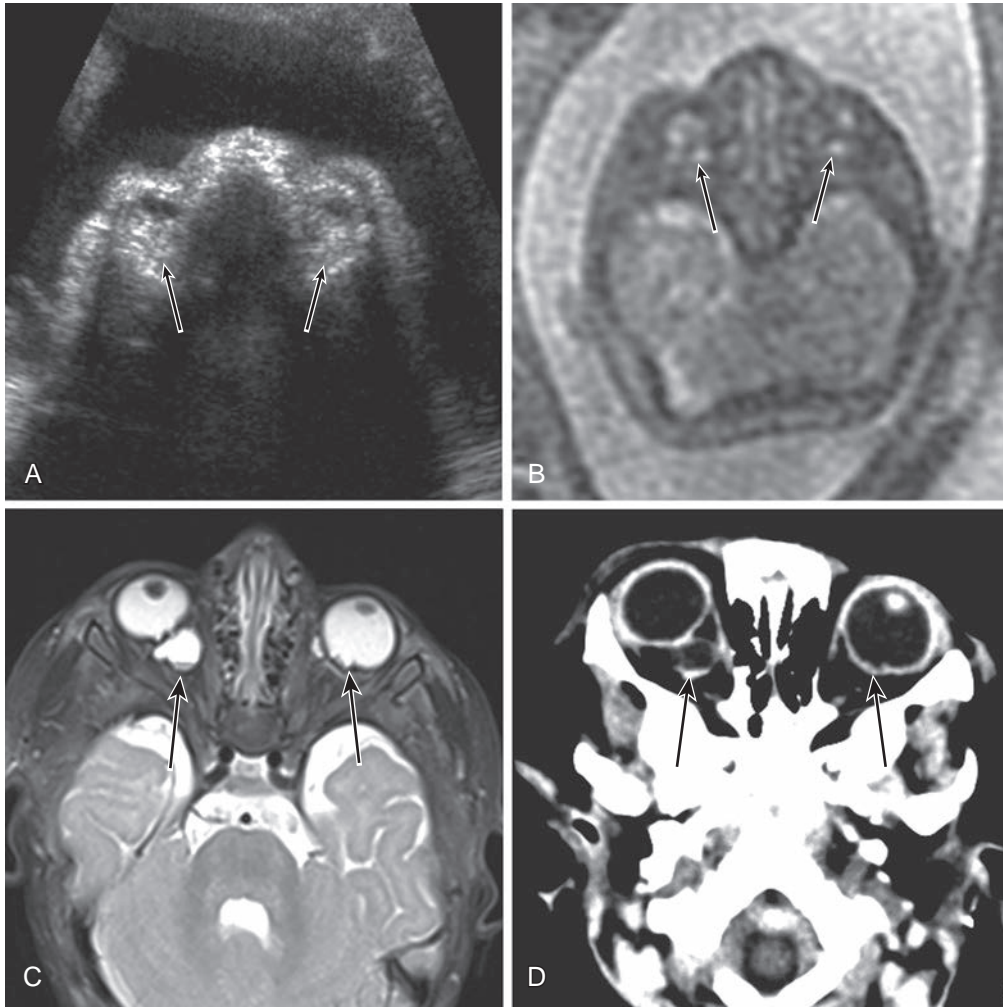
Coloboma. (A) Prenatal ultrasound image demonstrates abnormal echogenicity of the globes (arrows), but the lenses appear relatively normal. (B) Axial fetal MRI shows bilateral, symmetric, abnormal globes with mixed low- and high-signal vitreous (arrows) and no definite lens structures. (C) Postnatal axial T2-weighted MRI shows bilateral cystic colobomata (arrows). (D) Noncontrast CT image showing cystic coloboma of the posterior right orbit (arrows). (B, From Robinson AJ, Blaser S, Toi A, et al. *Magnetic resonance imaging of the fetal eyes—morphologic and biometric assessment for abnormal development with ultrasonographic and clinicopathologic correlation*. *Pediatr Radiol*. 2008;38:971–981.)
